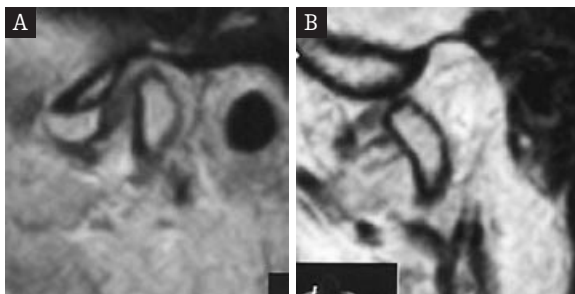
MRI of the TMJ. Locked anterior disc displacement. III° in Wilkes score.
